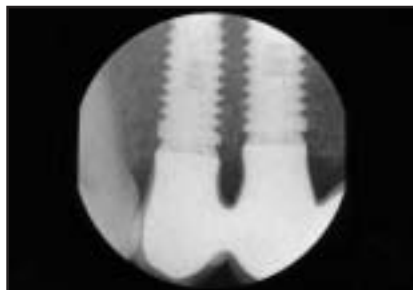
Superimposed radiographic and clinical images demonstrate relationship between bone and soft tissues and the presence of bone peak coronal to implants' shoulders despite the interimplant distance of about 3 mm.
